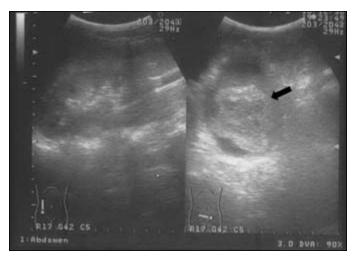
Sonography revealed intrabladder blood clot formation (arrow).
